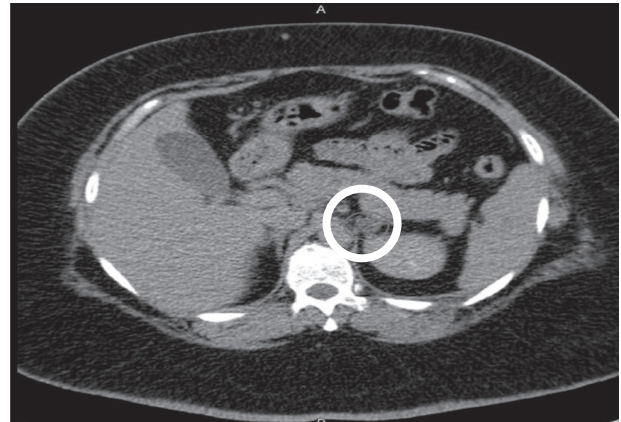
CT Adrenal Revealing 1.3cm Left Gland Incidentaloma (Lesion Encircled)
